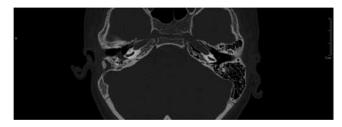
Post-operative temporal bone CT scan of case 1.
